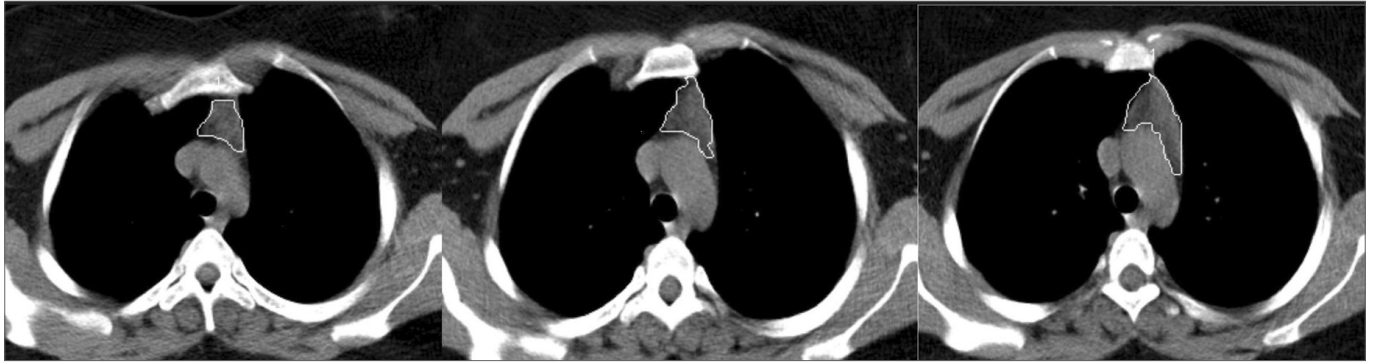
The volumetric contours of the thymus on CT slice.
